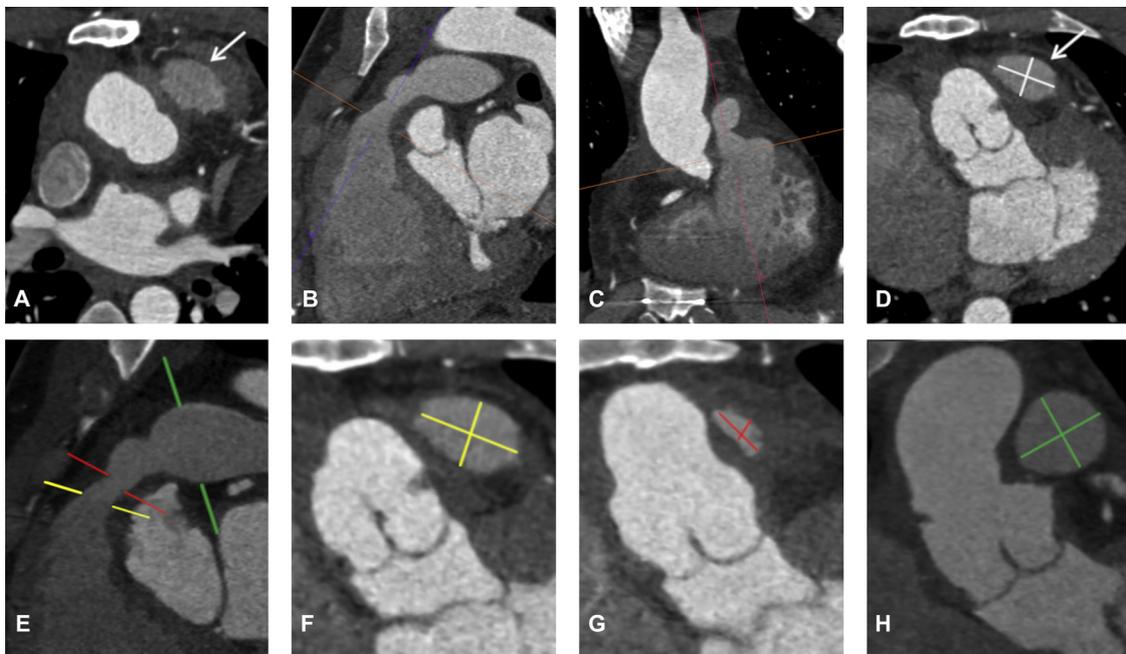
CT Analysis: Assessment of the pulmonary trunk size.
